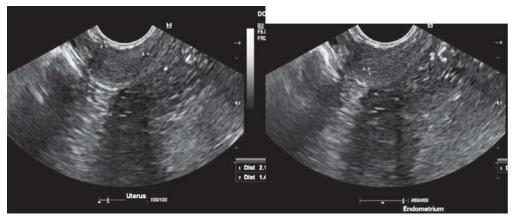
Transrectal and transabdominall ultrasound: The uterus and endometrium. The uterus is retroverted with smooth contour and homogeneous echopattern measuring 3.6cm x 1.8cm x 1.4cm. The endometrium is linear measuring 0.2 cm, with intact subendometrial halo.
